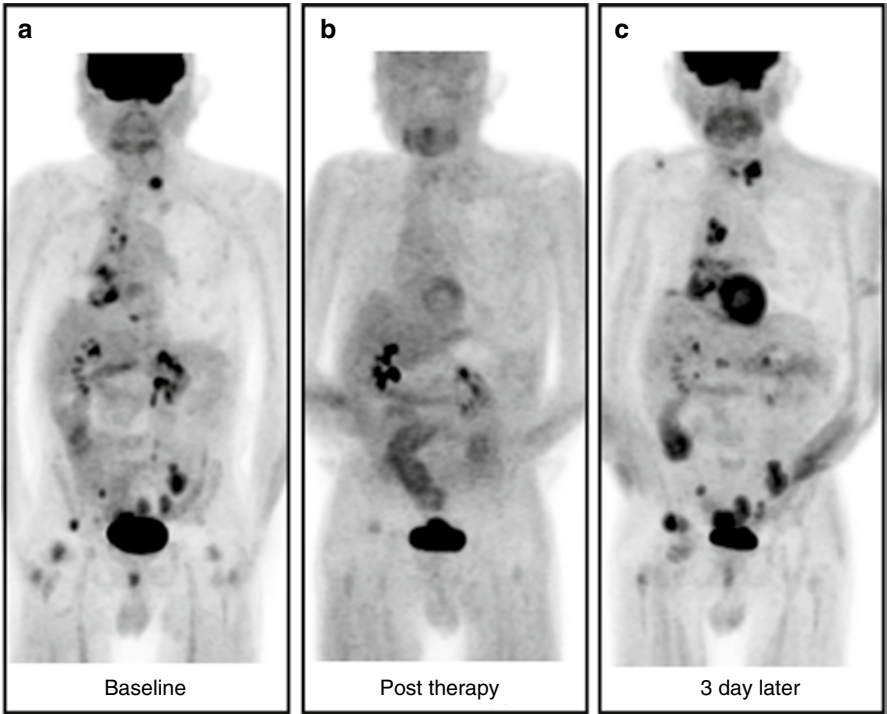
A 76-year-old male with lung cancer. Anterior MIP (maximum intensity projection) images from sequential FDG PET-CT studies. (a) The baseline study shows widespread metastases. The blood glucose was 105 mg/dL. (b) Post-therapy (11 weeks later), the metastases appear to have resolved. Of note, there is very little FDG uptake in the brain. The patient was not known to be a diabetic, but the blood glucose was 260 mg/dL. (c) The patient was sent to his physician for treatment of newly diagnosed diabetes and the FDG study was repeated 3 days later. At the time of the repeat study, his blood glucose was 76 mg/dL. In comparison to the baseline study, the repeat study demonstrates progressive metastatic disease and normal brain uptake. The elevated blood glucose level at the time of the initial post-therapy study is probably insufficient to fully explain the essentially complete lack of uptake in the metastases and brain. It is postulated that, in addition to a possible competitive effect, the elevated glucose level caused a downregulation of the glucose receptors in tumor and the brain
